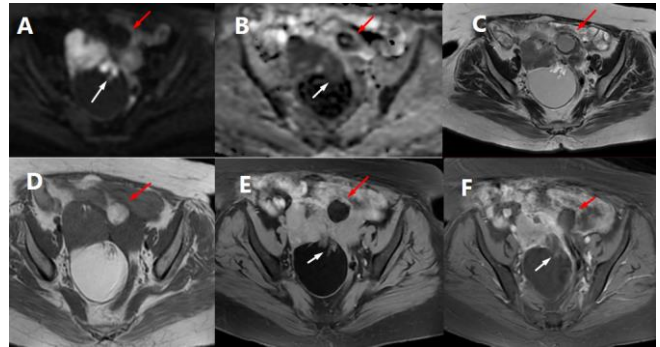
(A) DWI, (B) ADC map, (C) Axial T2, (D) Axial T1 pre-contrast, (E) Axial fat sat T1 pre-contrast WIs, (F) Axial fat sat T1 post-contrast show bilateral ovarian mature cystic teratoma. Large right ovarian complex solid/cystic lesion, In DWI, the cystic component displays low signal (A) ADC map low signal (B), heterogenous bright signal in T2 (C), high signal in T1 (D), marked low signal in T1 fat sat (E), no post-contrast enhancement (F). The solid component (White arrow) shows DWI bright signal and ADC map low signal, (Restricted diffusion), T2 bright signal, T1, and T1 fat sat low signal and no post-contrast enhancement. Smaller left ovarian mature cystic teratoma (Red arrow), shows a mainly cystic component displays DWI bright signal and ADC map low signal, (Restricted diffusion), T2 heterogenous bright signal, T1 bright signal, T1 fat sat marked low signal and no post-contrast enhancement. The solid right ovarian lesion component ADC value is around $0.9 \times 10^{-3} \text{ mm}^2/\text{s}$.
